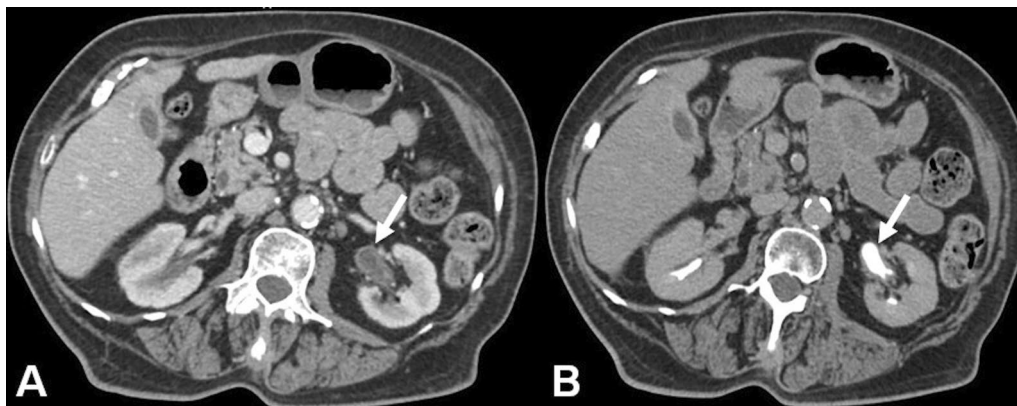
A Enhanced CT scan of the abdomen and pelvis, axial cross section during the nephrogenic phase, showing significant decrease in the pelvicalyceal and ureteral wall thickening bilaterally, with almost complete resolution (arrow). Note as well the significant decrease in perinephric fat streaking after antibiotics administration. B Another axial view during the delayed phase also showing complete resolution of urothelial thickening with absence of any filling defects (arrow)
